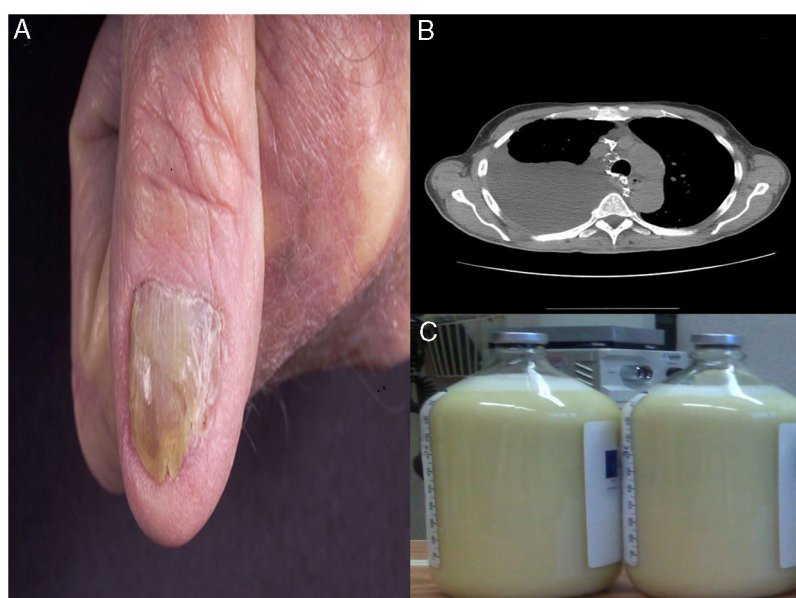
(A) Yellow dystrophic fingernails. (B) Computed Tomography of the chest demonstrated large right-sided pleural effusion. (C) Milky white “Chylous” pleural fluid.
